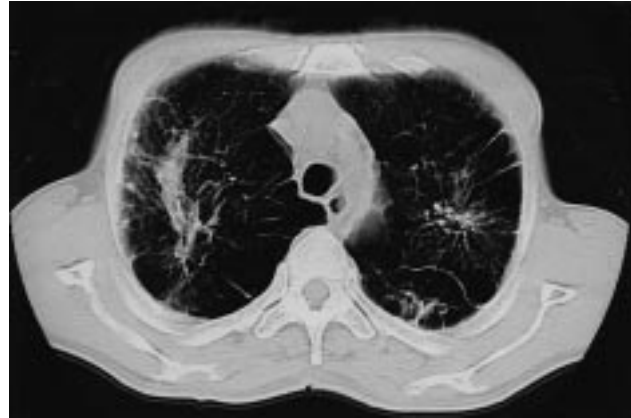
Chest CT scanning shows a typical large opacities induced silicosis in the upper lung field and left upper lung field also.
